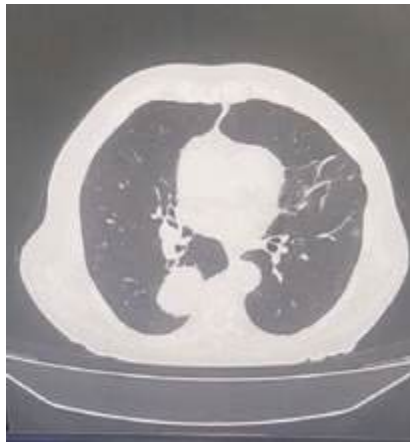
Axial HRCT image (lung window setting) showing a pulmonary mass in a patient without radiological evidence of emphysema
